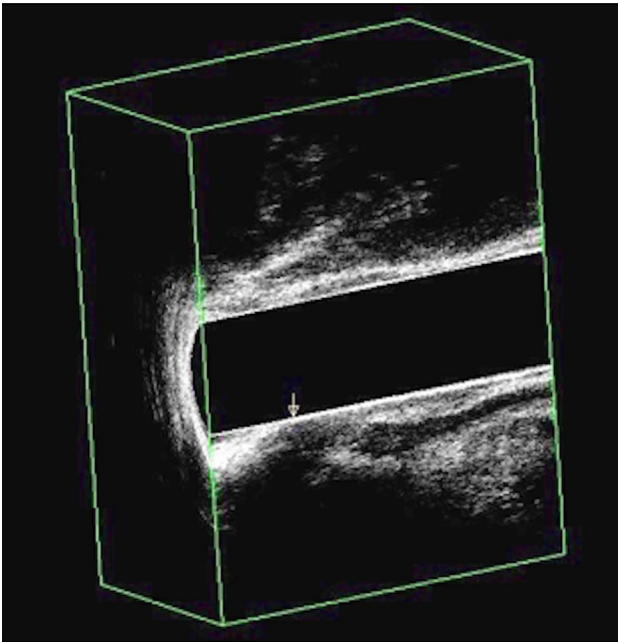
Tridimensional endoanal ultrasound in sagittal view of a female patient complaining for obstructed and painful defecation related to anal hypertonia, showing a posterior anal fissure evolving in a superficial abscess (arrow)
